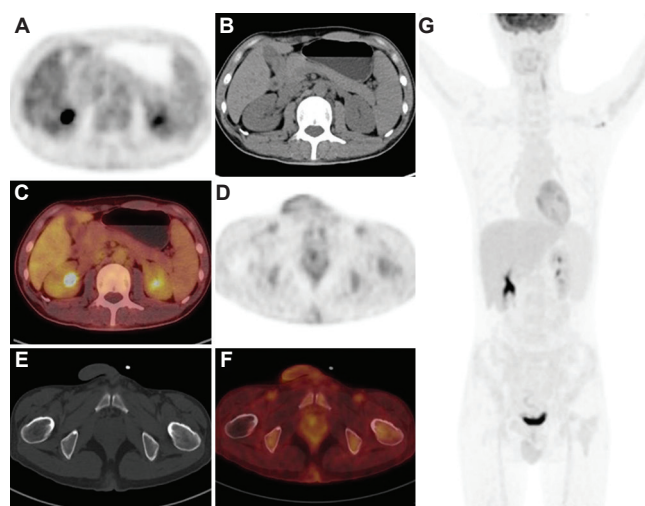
After two cycles of chemotherapy, a repeat PET/CT showed that all previous hypermetabolic lesions disappeared. Panel A–C showed PET, CT, and PET/CT fusion images of both kidneys, respectively. Panel D–F showed PET, CT and PET/CT fusion images of the left femoral neck, respectively. (G) displayed MIP image of the whole body.
